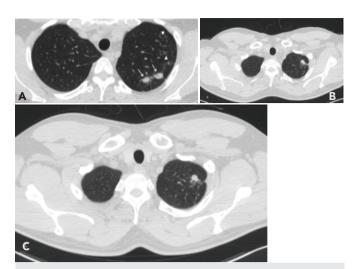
A 35-year-old male. (A) Non-contrast computed tomography (CT) image shows two nodules (arrows) that were decided to be followed-up. Anteriorly centrilobular nodules (arrowhead) may suggest an active infectious process. (B) 6th month control CT of left upper lobe shows new nodule in the area where centrilobular nodules were previously seen. (C) Follow-up CT after 20 months shows a decrease in size of the nodule
